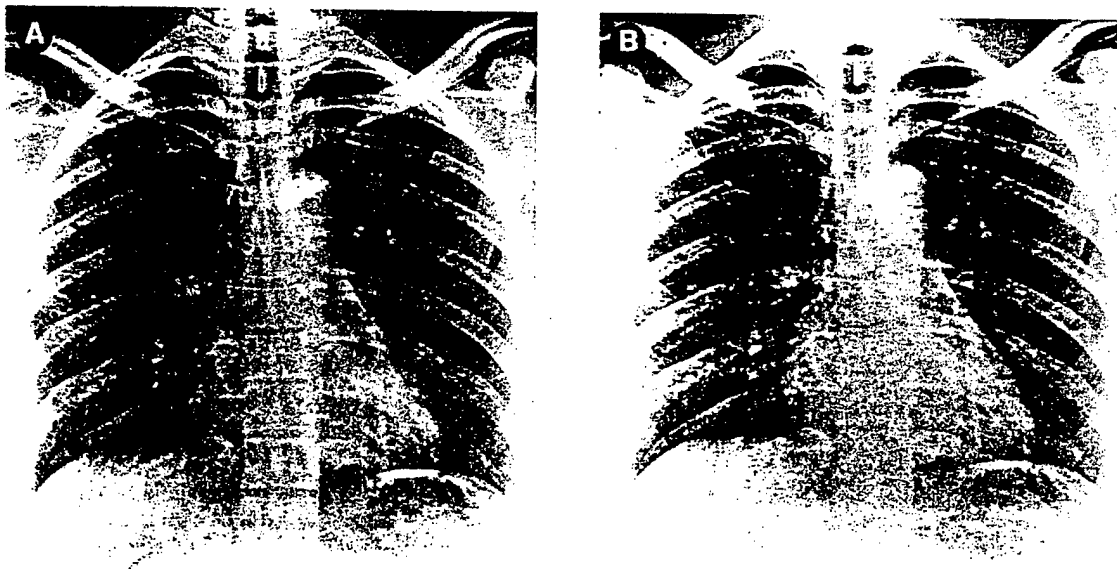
A normal chest radiograph printed with two different look-up tables. (A) This chest is printed with a chest look-up table. The contrast is lower than that in Fig 5B. The lungs are less black, and the spine is less white, so that more details can be seen in the lungs and upper abdomen. The GA of 0.6 is lower than in B, resulting in lower contrast (GA = 0.6, GT = D, GC = 1.6, GS = -0.30, RN = 4, RT = R, RE = 0.5). (B) The same chest radiograph is printed with a look-up table used for abdominal radiographs. The contrast is higher. The more central portions of the lungs are darker. The abdominal region is less visible because it is too light. The GA of 0.9 is higher than in A, resulting in higher contrast (GA = 0.9, GT = D, GC = 1.6, GS = -0.30, RN = 4, RT = R, RE = 0.5).
